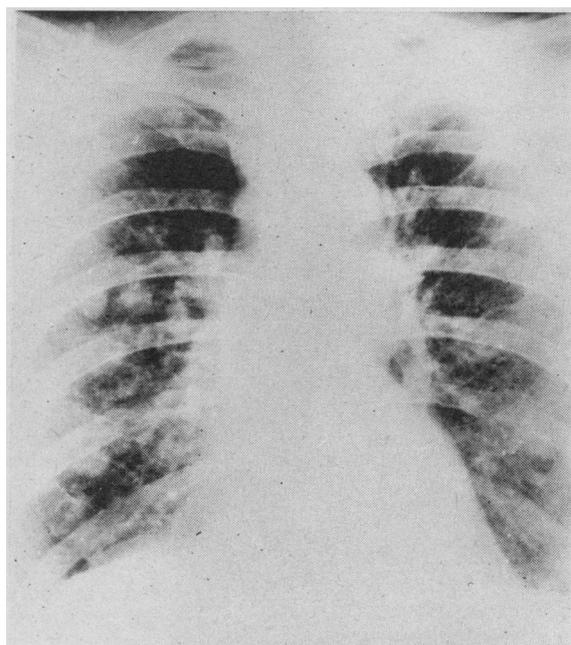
X-ray of chest showing well-defined metastatic deposits in the lung fields.
